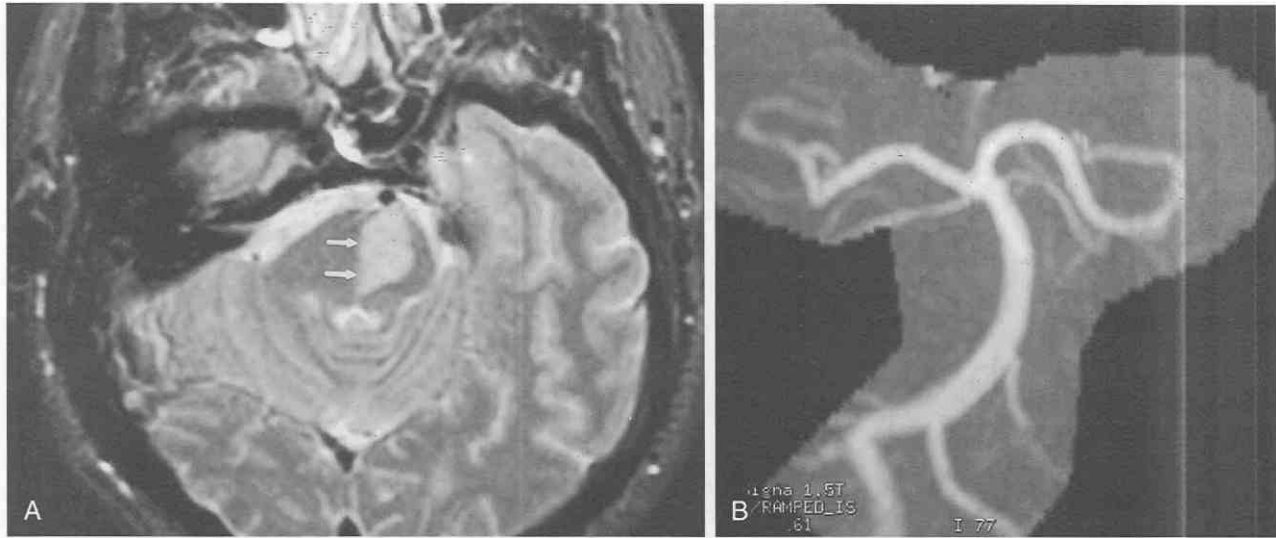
Acute paramedian perforator infarct. A, T2-weighted axial image shows increased signal within the central pons. The medial border of this infarct does not cross the plane of the midline. This tendency to respect the midline is typical of paramedian branch infarction. B, Three-dimensional time-of-flight MRA shows no narrowing of the basilar artery in this patient with small-vessel infarction.
